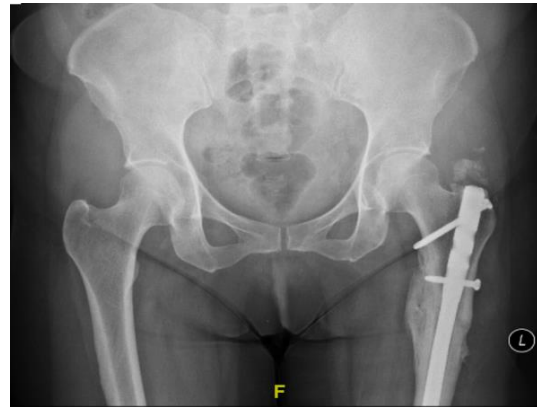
Xray post Intramedullary Nailing
